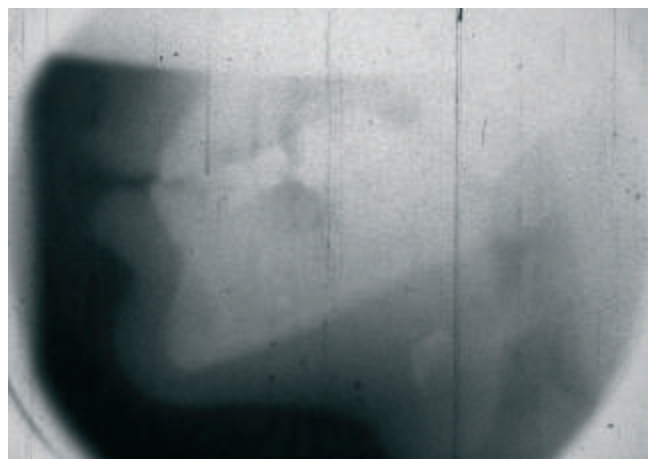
Still from Ballard's cine radiographic recordings of tongue function. (These recordings are archived at the BOS and are available for viewing.)
